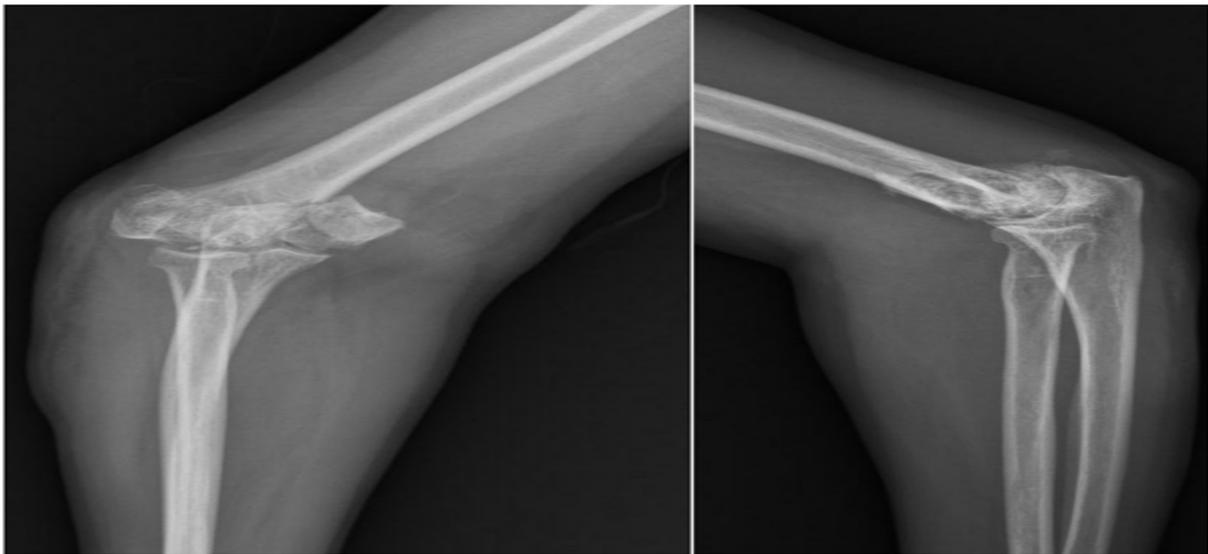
X-rays immediately after trauma showing comminuted intra articular distal humerus fracture.
